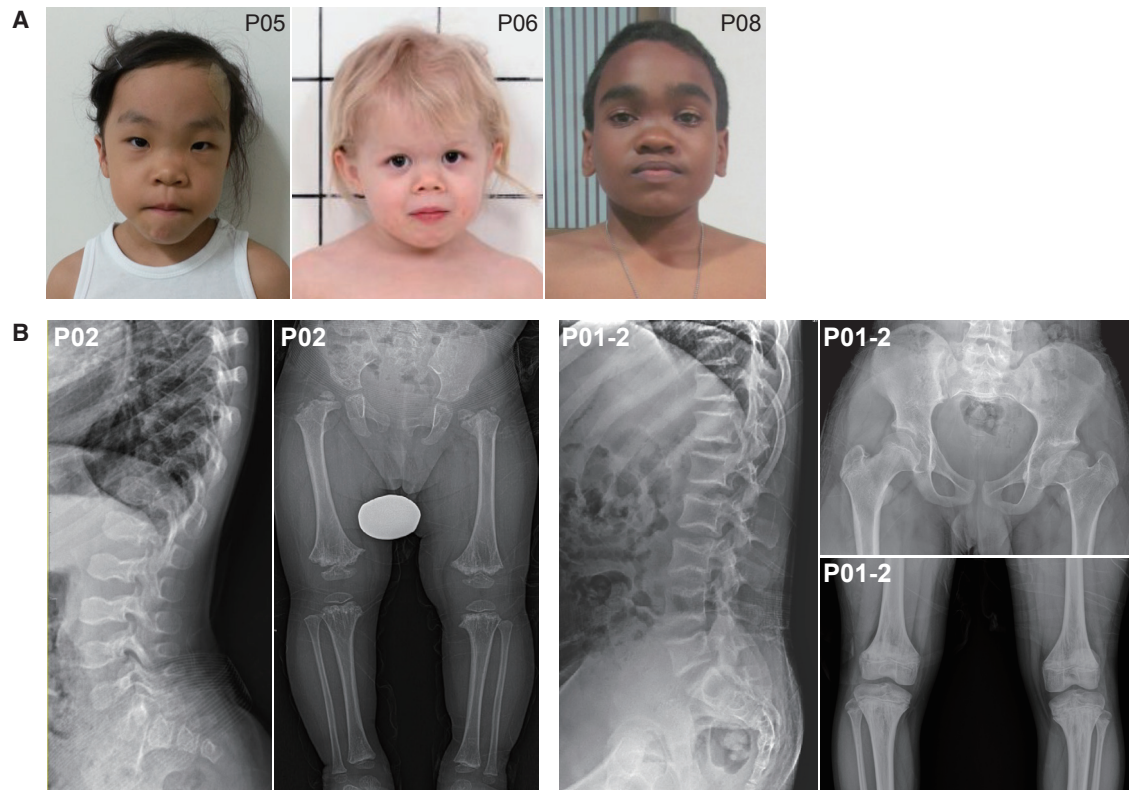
Characteristic Facial Appearance and Radiographic Findings of Individuals with SPONASTSRIME Dysplasia
